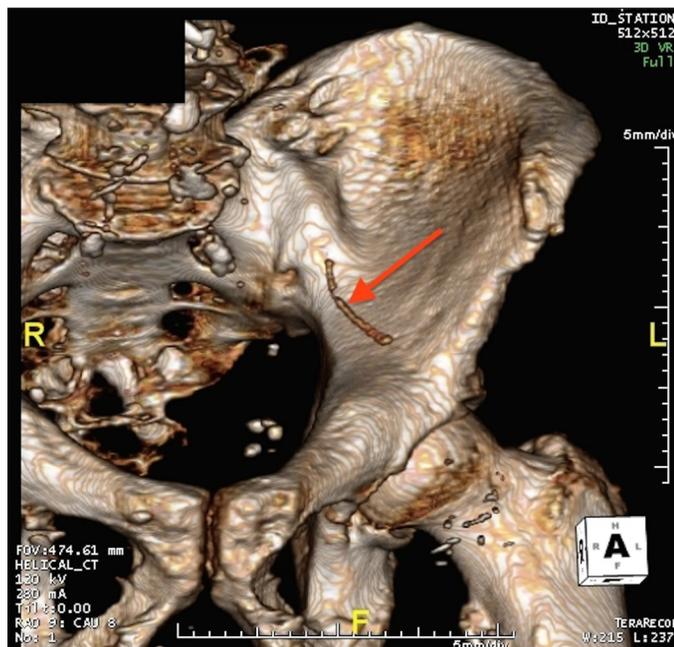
3D reconstruction from computer tomography angiogram (CTA) imaging showing gracile bone impaction (red arrow).
